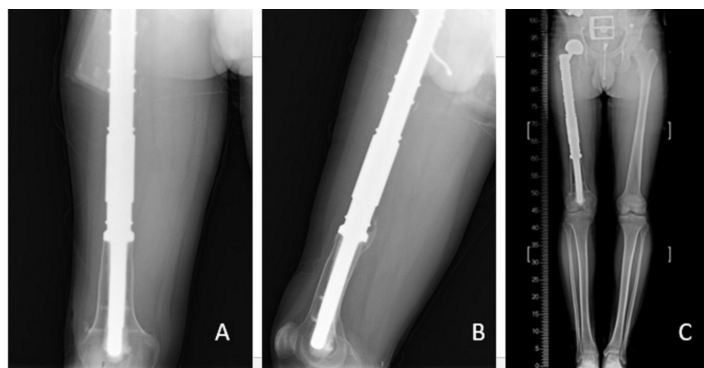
30 cm segment of bone was resected and reconstructed limb with the cemented endoprosthesis (intercalated) implant, shown on (A) the anterior-posterior, (B) lateral and (C) leg-length radiographs
